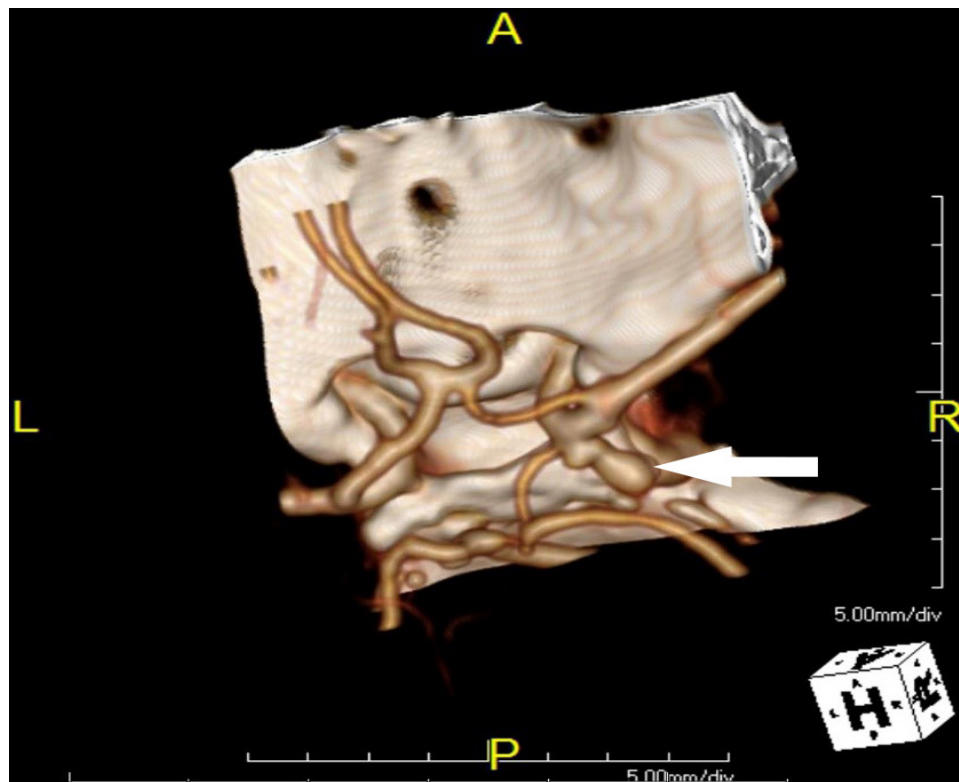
Three-dimensional contrast enhanced computed tomography reconstruction showing bilobed right posterior communicating artery aneurysm.
